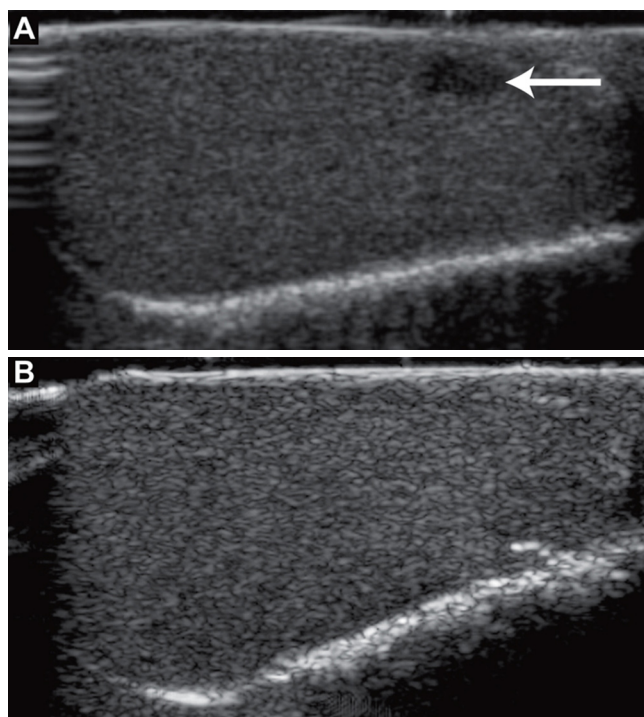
Intraoperative sagittal sonogram localizes the 3-mm nodule to the closest surface of the testis. B. Intraoperative sagittal sonogram performed after surgical removal of the nodule shows no residual mass.
